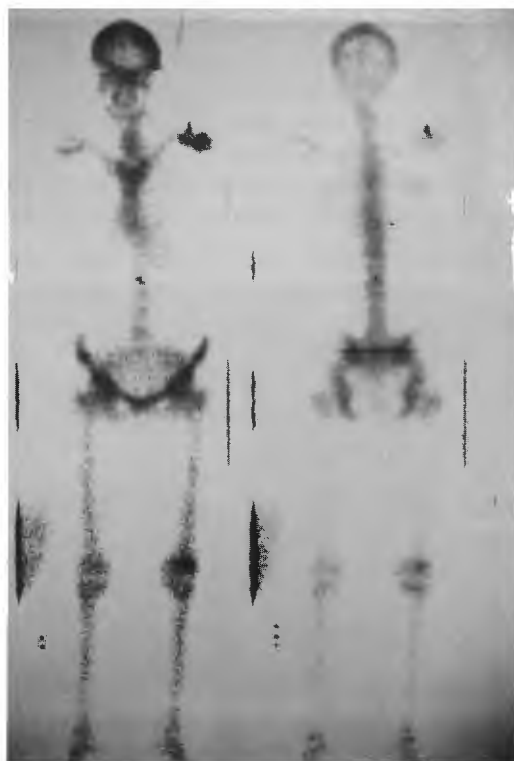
Diffuse bony metastases with relatively normal-appearing scan showing "missing kidney" sign. Patient with radiographically demonstrated diffuse bony metastases from breast carcinoma. Bony structures (except possibly the skull) appear normal on scan. The absence of kidney visualization is the prime clue that an abnormality is present (see text for further explanation).
